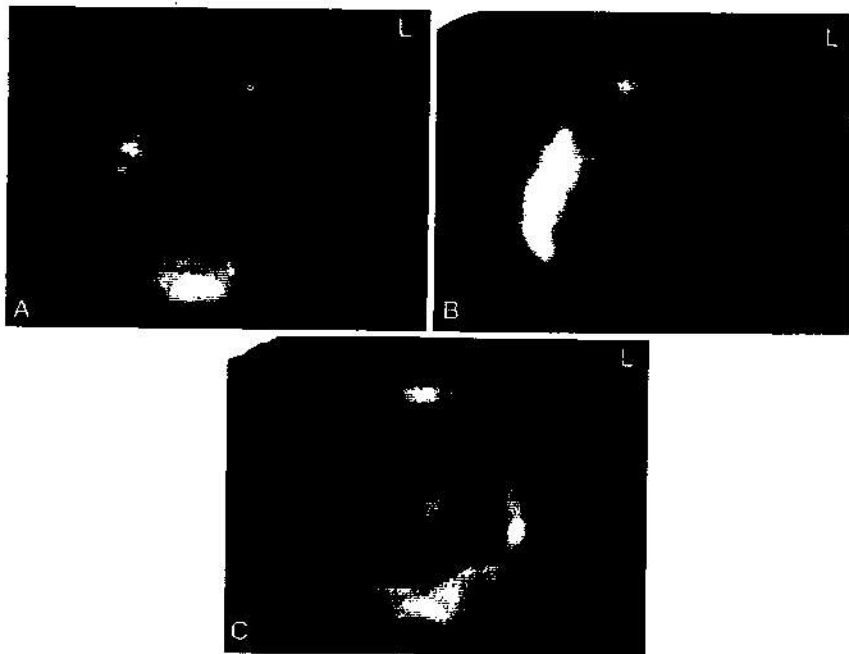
SPECT in HSV encephalitis: case examined with HM-PAO. A, a clearly hyperperfused area in the right anterior and middle temporal lobe 4 days after onset of encephalitis. B, the rate of hyperperfusion has increased, and the area covers also the posterior temporal aspects 12 days after onset. C, an area of hyperperfusion is seen 55 days after onset in the corresponding area where initial hyperperfusion was seen. (Courtesy of Launes J, Nikkinen P, Lindroth L: *Lancet* 1:1188-1191, May 28, 1988.)
